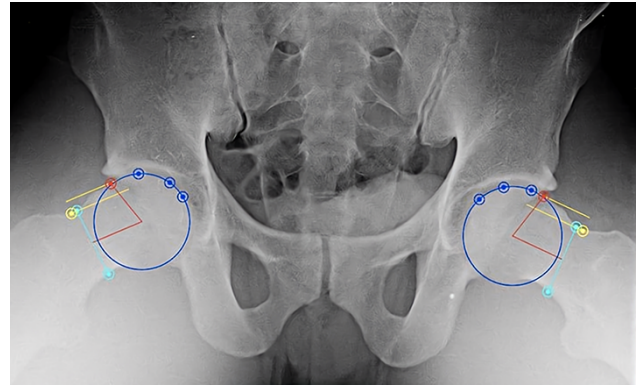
Radiograph of the modified Dunn lateral view with OsiriX measurements of  $\alpha$ -angle (red).
